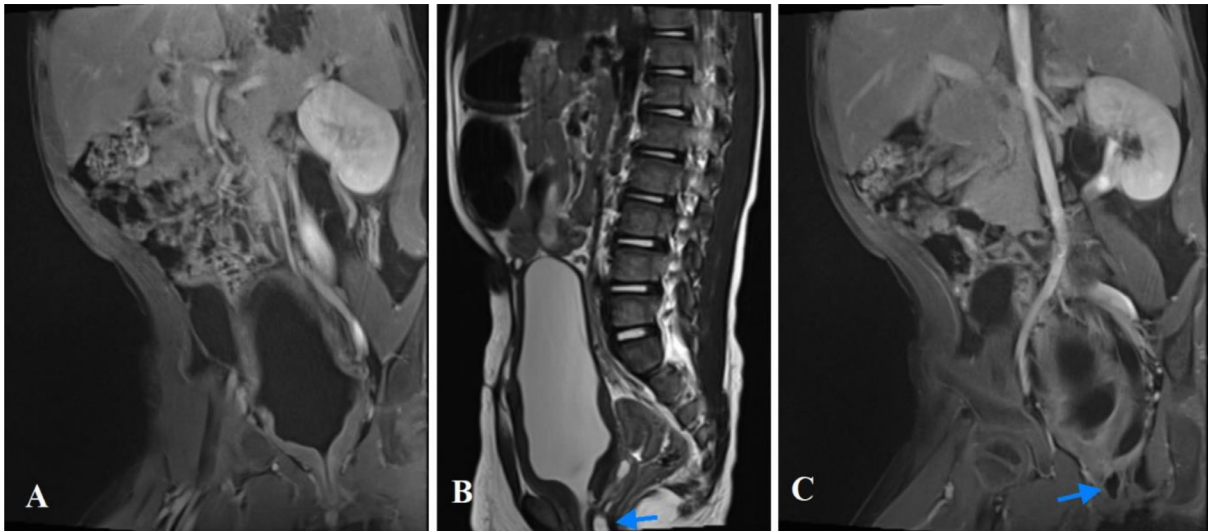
(A) Contrast-enhanced T1-weighted image with fat saturation showed the hypertrophic bladder neck. (B) Sagittal plane of T2-WI showed the urethral diverticulum on the posterior urethral wall (blue arrow). (C) The diverticulum (blue arrow) demonstrated no enhancement.
